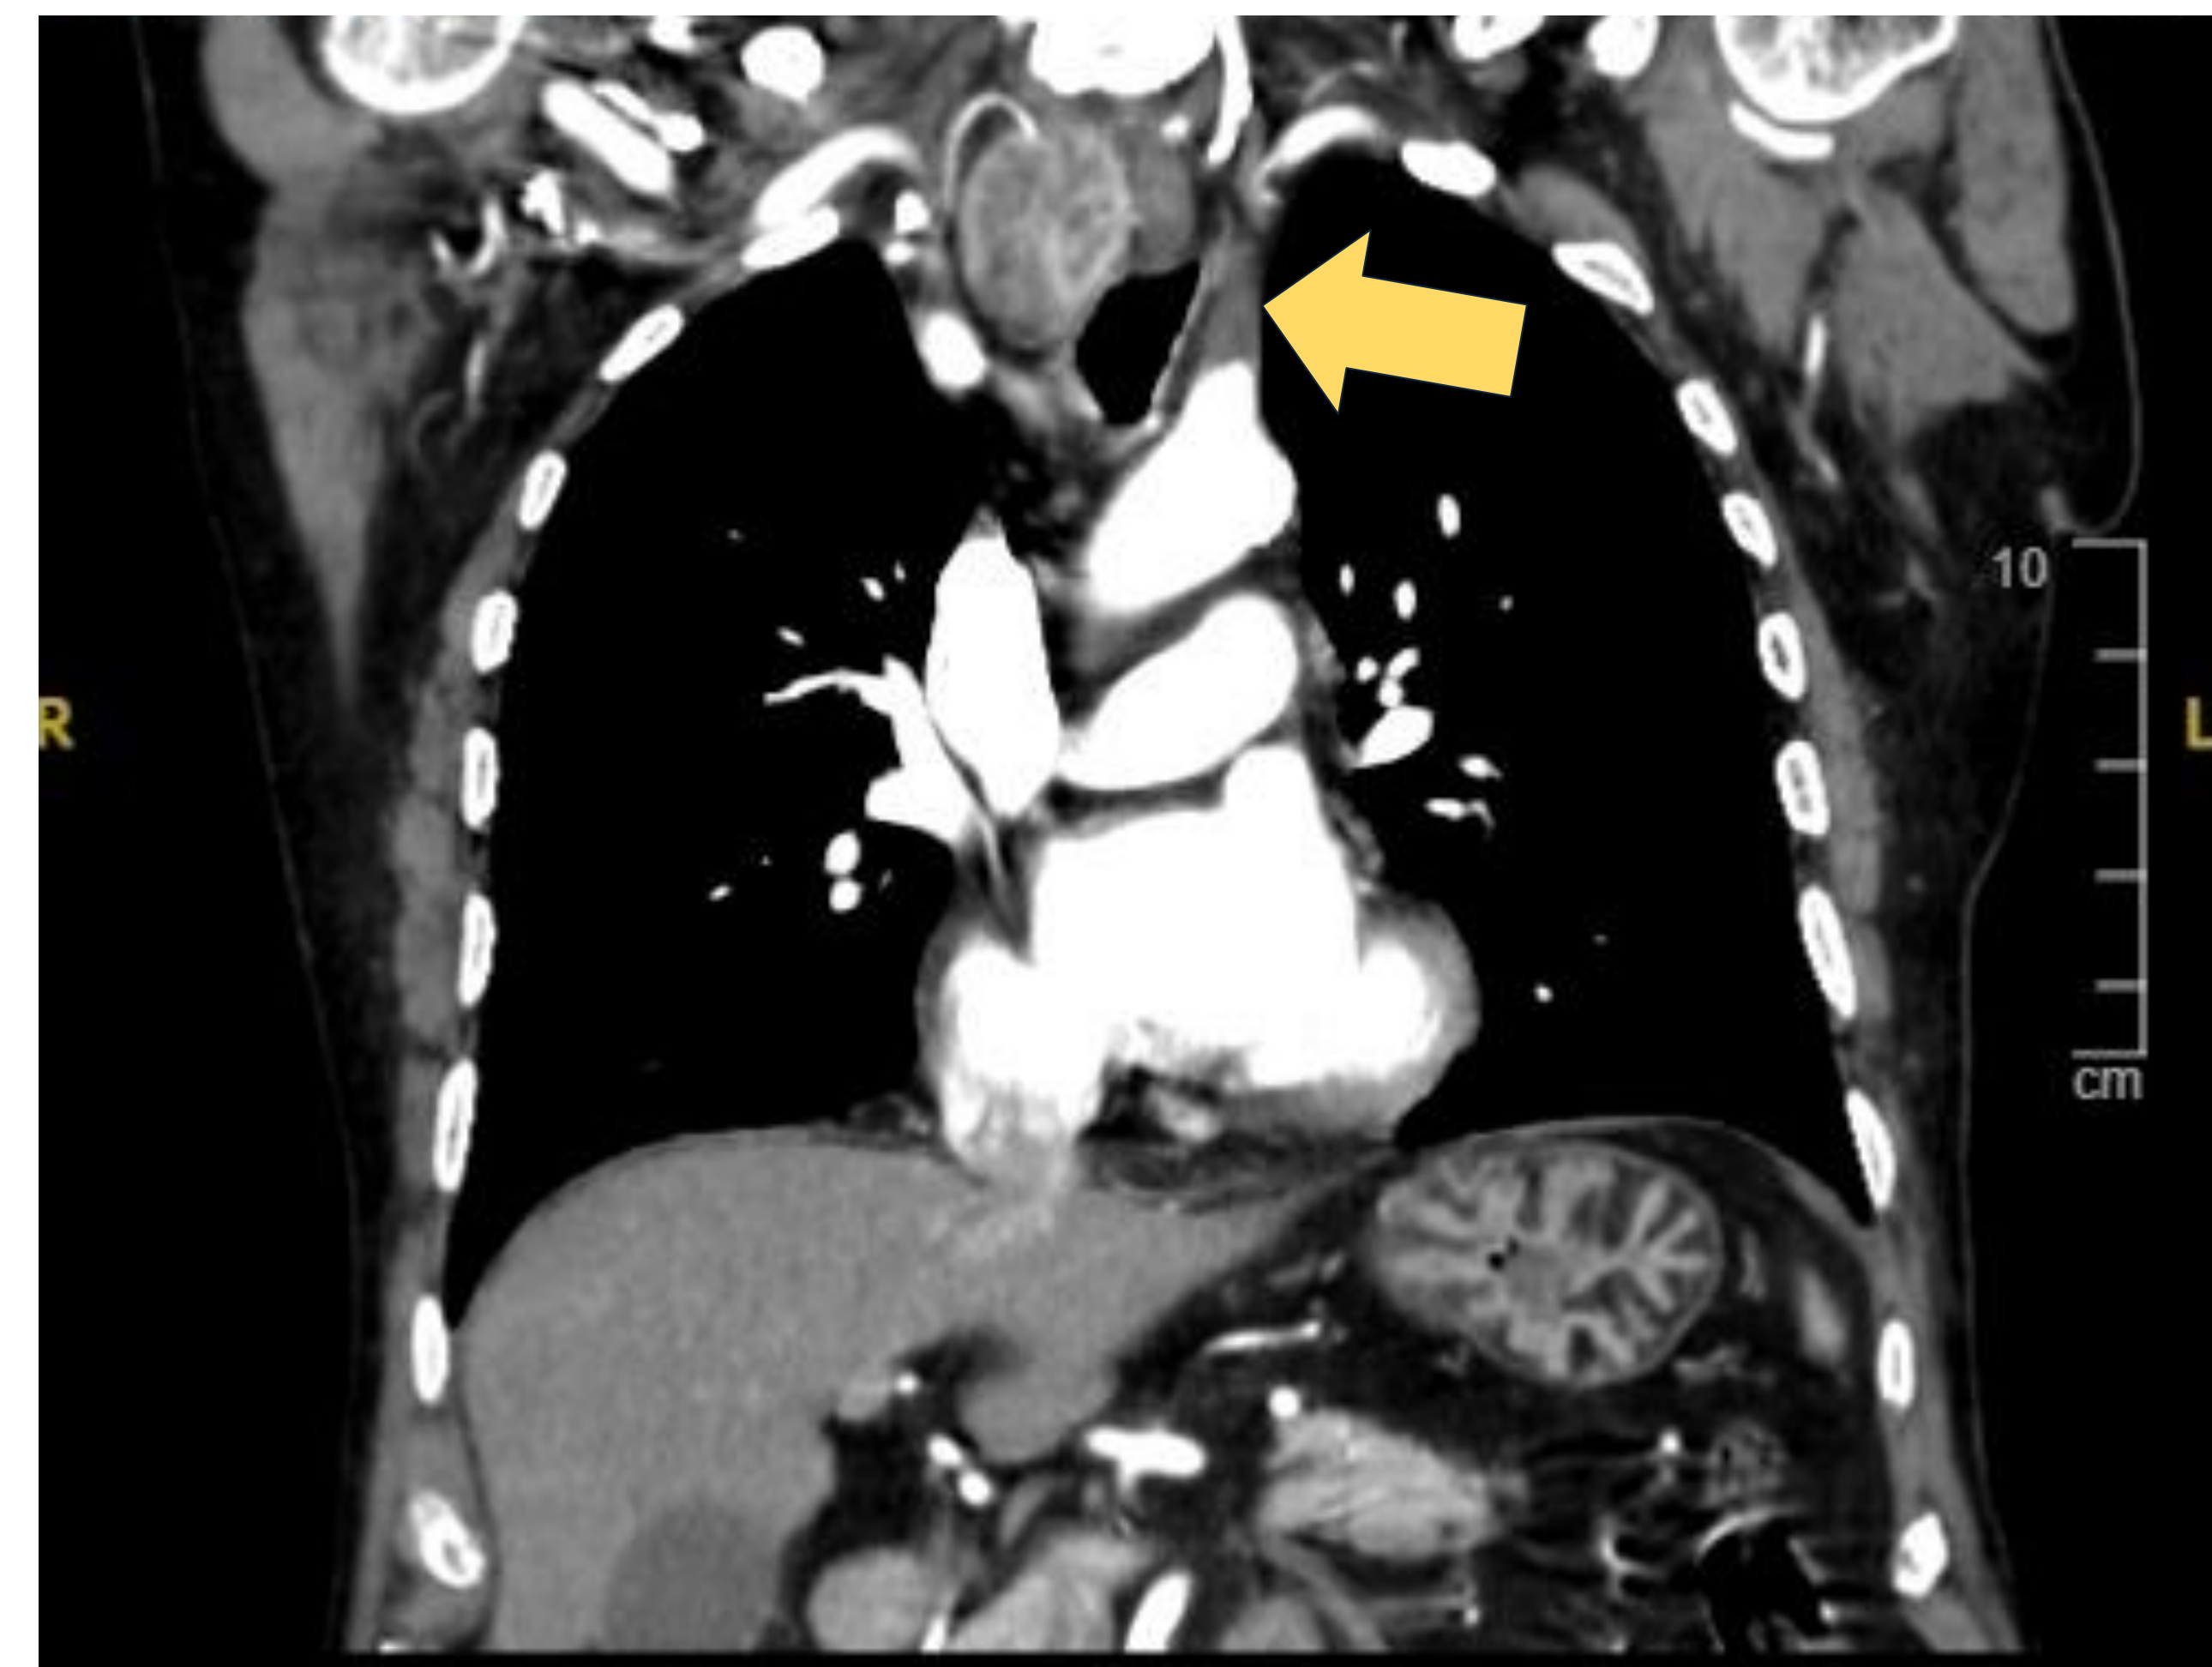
CT angiography showing evidence of complete proximal left subclavian occlusion
